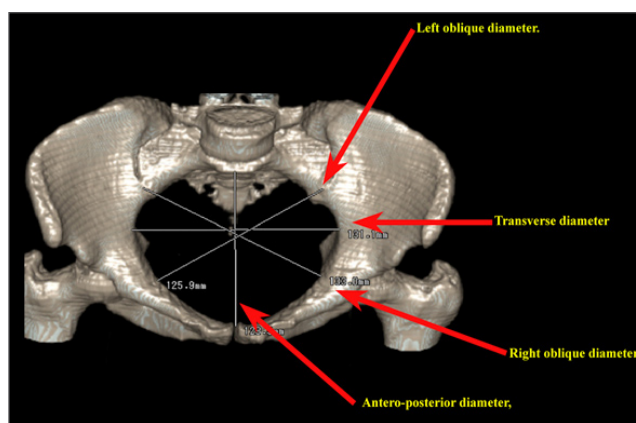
Antero-posterior examination (from superior aspect) of a reconstructed CT pelvis. In the image the various measurement /references that are taken for the analysis at the Inlet of the pelvis were shown.
